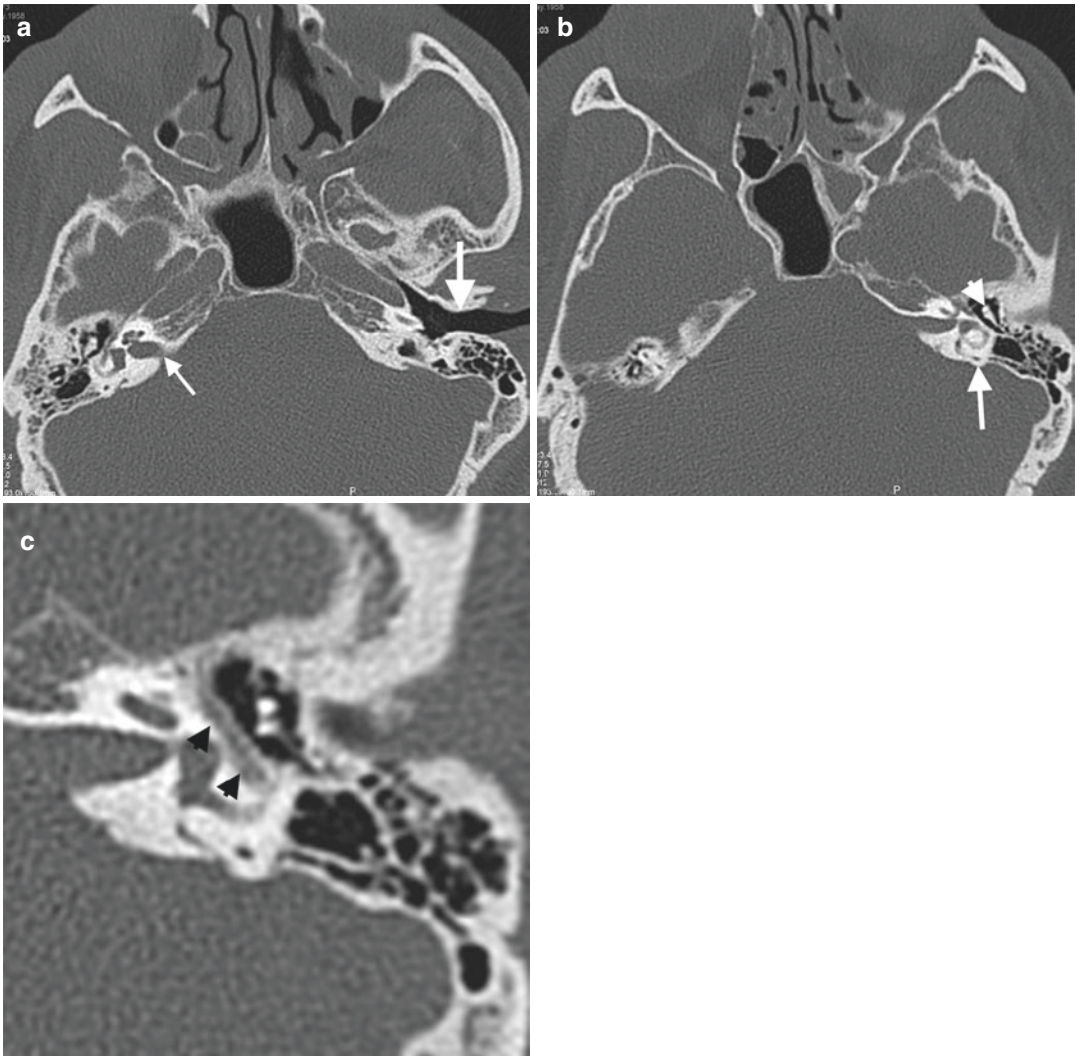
Temporal bone anatomy. (a) Axial CT image at bone window demonstrates left EAC (thick arrow) and right inner ear (thin arrow). (b) Ice cream appearance of incudomalleal complex (arrowhead) in tympanic portion and otic capsule (arrow) in the left temporal bone. Ice
